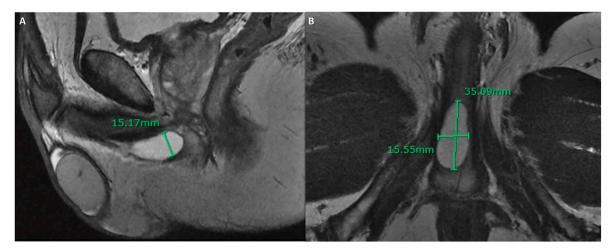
MRI Cowper's Gland Syringocele A: Sagittal view, B: Transversal view.
